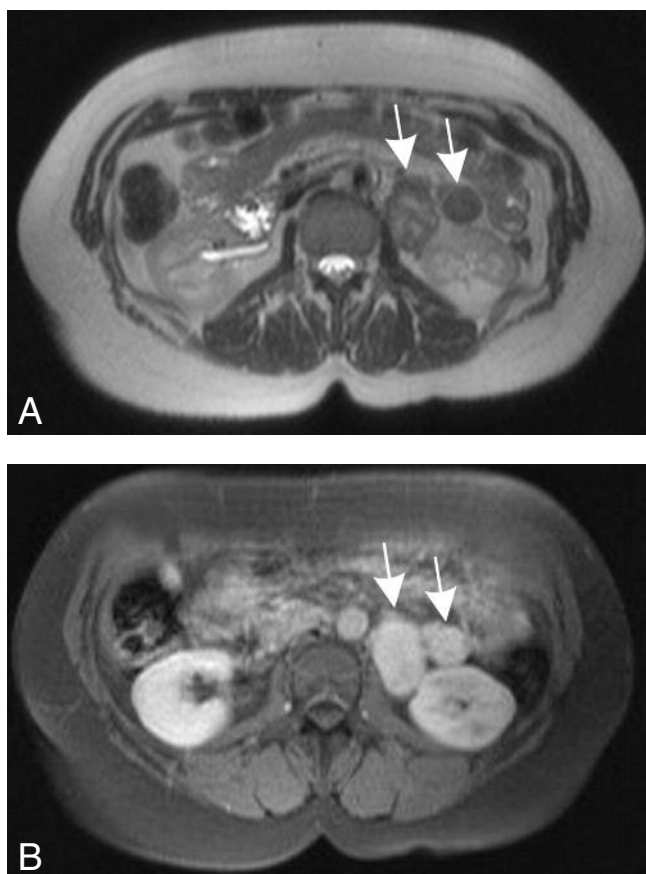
MRI of the abdomen shows iso-intensity of the lesions with skeletal muscle (A). After Gadolinium injection there is heterogeneous enhancement in the early phase (B, 30 sec), gradually progressing to homogenous enhancement on the late phase (C, 90 sec).
